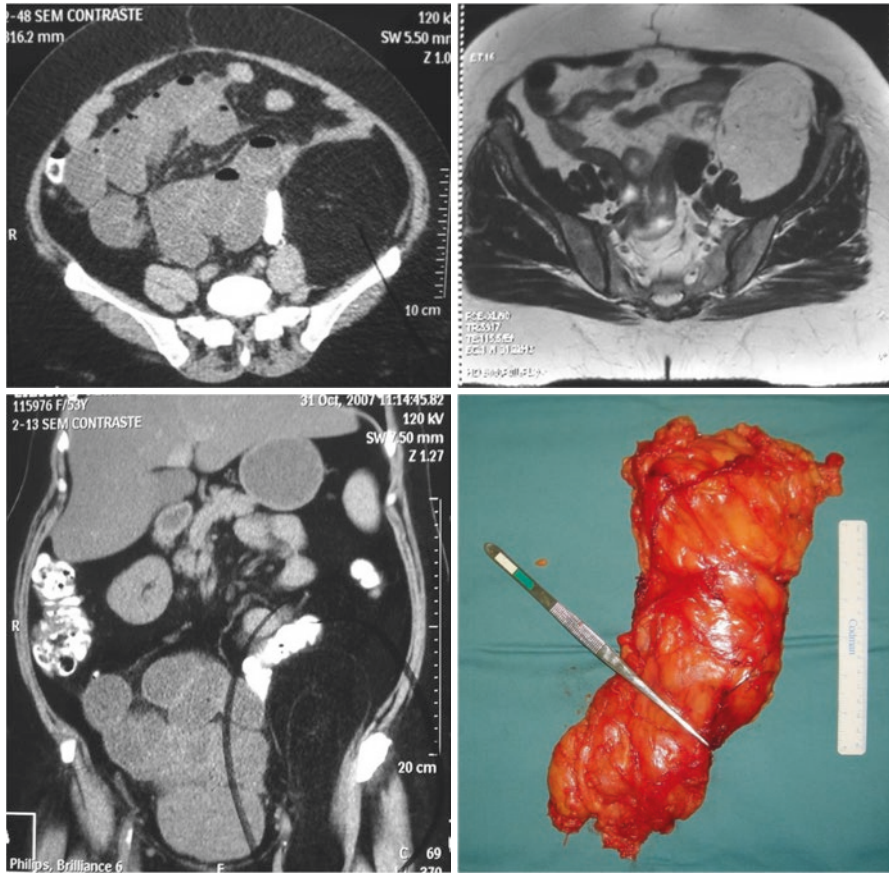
A 53-year-old female patient complaining of bulging in the right iliac fossa. MRI shows a homogeneous lipomatous lesion in the left pelvic topography projecting to the left thigh. Definitive pathological diagnosis of lipoma
